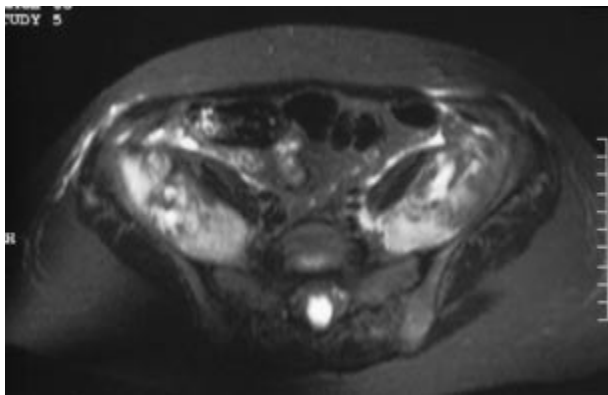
Magnetic resonance imaging (MRI) scan showing bilateral iliopsoas hemorrhage
